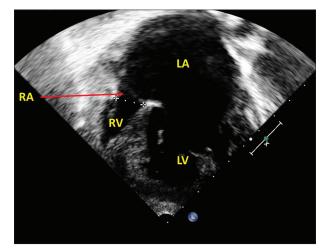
Transthoracic echocardiogram in apical four-chamber view shows severe hypoplasia of the right atrium and right ventricle
